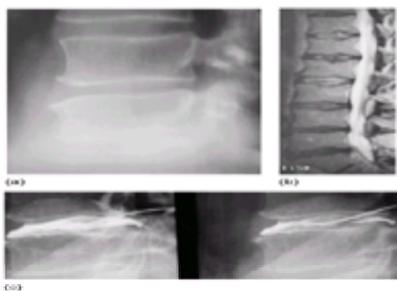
Disc degeneration. (a) Plain tomography showing disc narrowing and anterior osteophytes. (b) MRI showing disc degeneration especially at L4/5. (c) Anterior and posterior annular tears at discography. Note vascular filling, presumably the result of superficial inflammation. Anteriorly, the contrast in the tear creeps over an osteophyte on the superior surface of the lower end-plate at that disc level.
